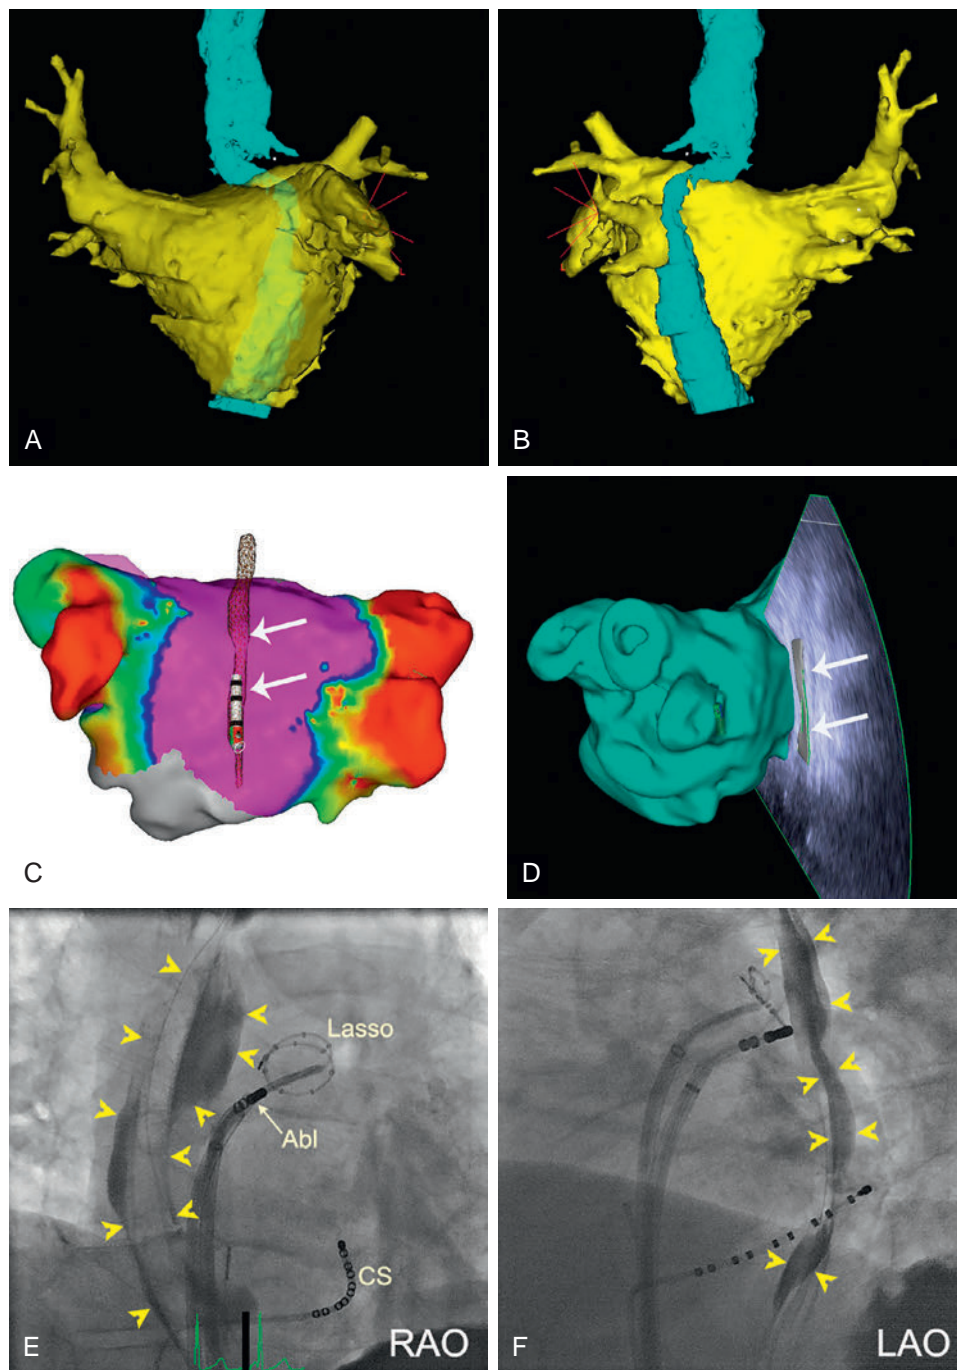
Assessment of Esophageal Location During Catheter Ablation of Atrial Fibrillation. (A and B) Anteroposterior and posteroanterior (PA) views of a computed tomography (CT) image of the left atrium (LA), pulmonary veins (PVs) and esophagus. The esophagus is visualized during CT scanning by the use of Gastrografin (contrast medium). Note that the real dimensions of the mid-segment are not very clear because of peristaltic movements and inadequate filling of the esophagus. (C) Electroanatomic (CARTO) map of the LA and PVs (PA view) incorporating reconstruction of the esophagus (*arrows*). The esophageal mapping catheter can also be visualized. (D) Electroanatomic (CARTO) map of the LA and PVs (left posterior oblique view). Intracardiac echocardiography is used to visualize the esophagus (*arrows*) and incorporate its location in the electroanatomic map (CARTO-Sound). (E and F) Fluoroscopic (right anterior oblique [RAO] and left anterior oblique [LAO]) views of the esophagus during catheter ablation of atrial fibrillation. Barium paste was given to the patient just before initiation of sedation for real-time visualization of the esophagus (*arrowheads*) during the ablation procedure. The ring (*Lasso*) and ablation (*Abl*) catheters are positioned at the ostium of the left superior PV. CS, Coronary sinus.
